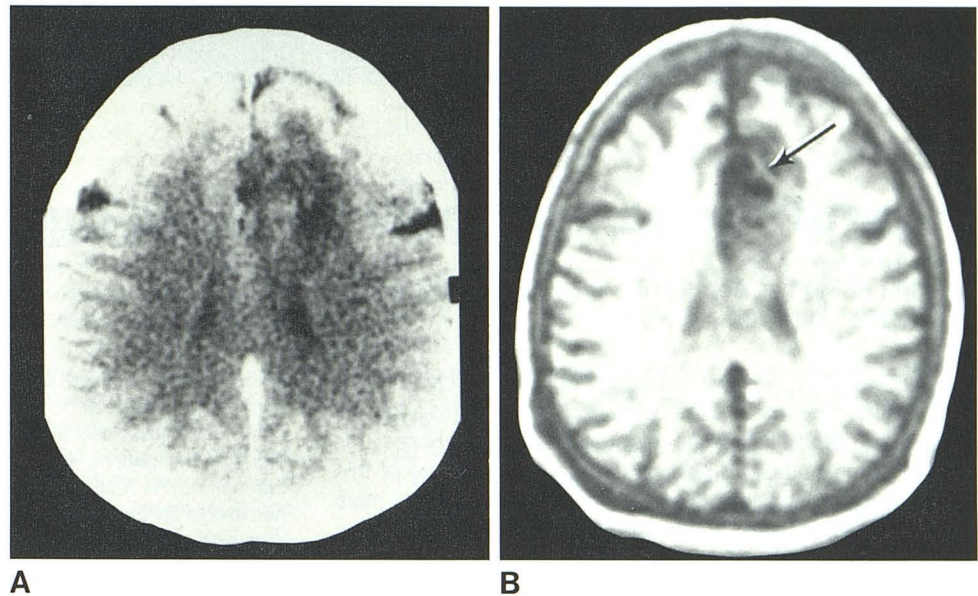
Case 2. Contrast-enhanced CT (A) and SE 1500/80 (B) scans. Abnormal area in B (arrow) was biopsied.
